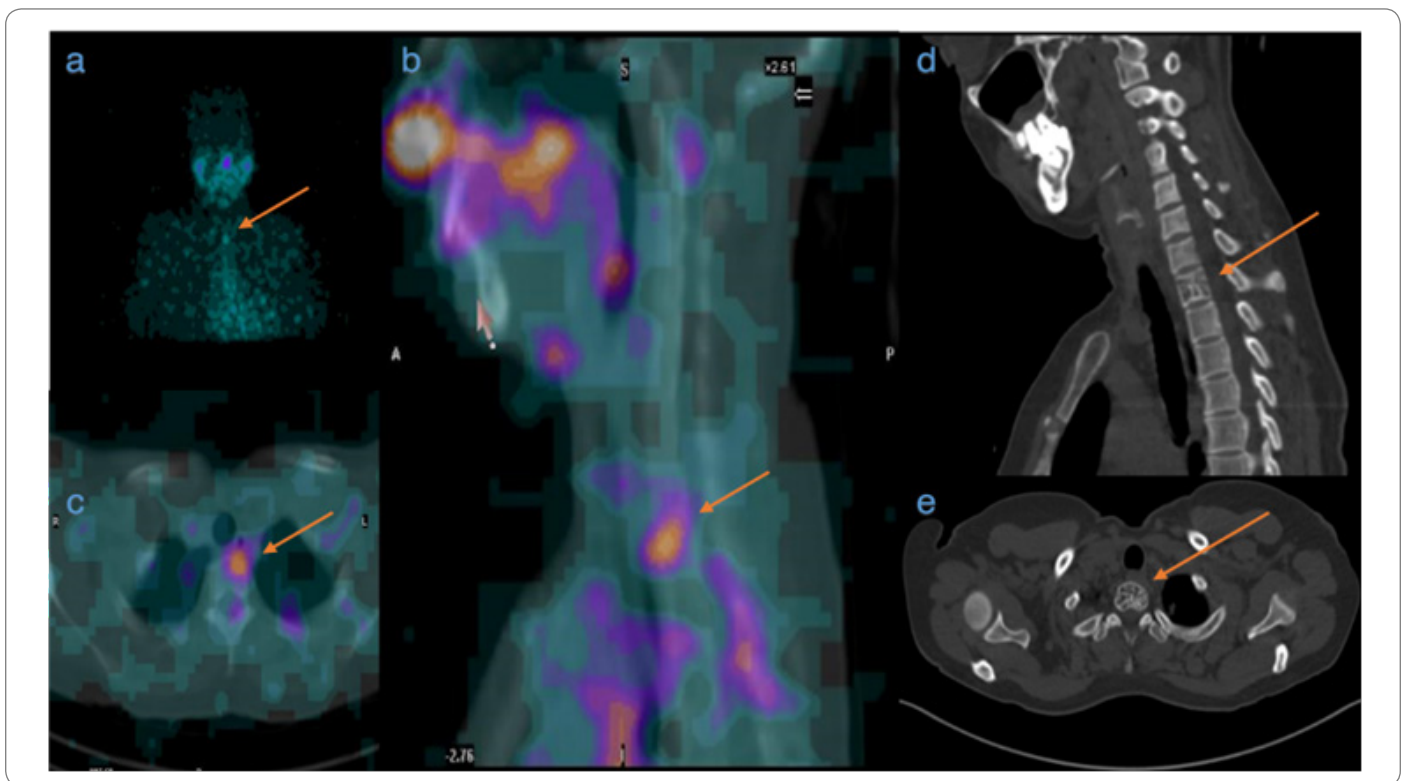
SPECT and fused SPECT/CT images of corresponding lesion (a, b, c) low dose CT images of corresponding lesion. (d, e). MIP SPECT image reveal ¹³¹I uptake in upper thorax. (a) SPECT image of sagittal and axial section confirms ¹³¹I uptake in D1 vertebrae (b, c); CT Sagittal section of D1 vertebrae reveal corduroy (d) and polka dot appearance of D1 thoracic vertebrae. (e) consistent with haemangioma.
